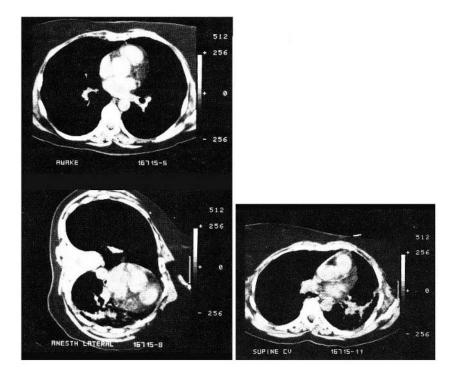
CT scan of a patient awake in the supine position (*upper panel*), after induction of anaesthesia in the lateral position and, finally, when turned to lie in the supine position during anaesthesia (*lower right*). Note the well-aerated lung while patient is awake and the formation of atelectasis in the dependent lung, whereas no atelectasis can be seen in the upper, nondependent lung during anaesthesia. Finally, when the patient is turned to supine there is still no atelectasis in the lung that was previously higher. For further details and explanations, see text. (From [9], with permission from the publisher)
